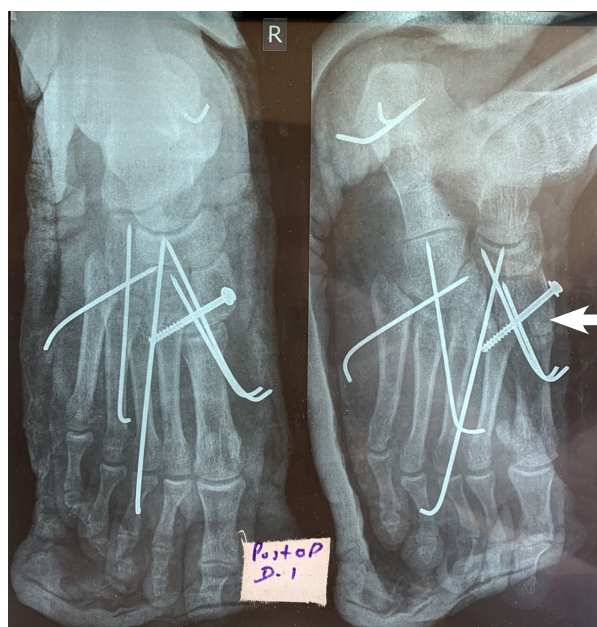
Post-operative X-ray showing well-reduced Lisfranc joint
